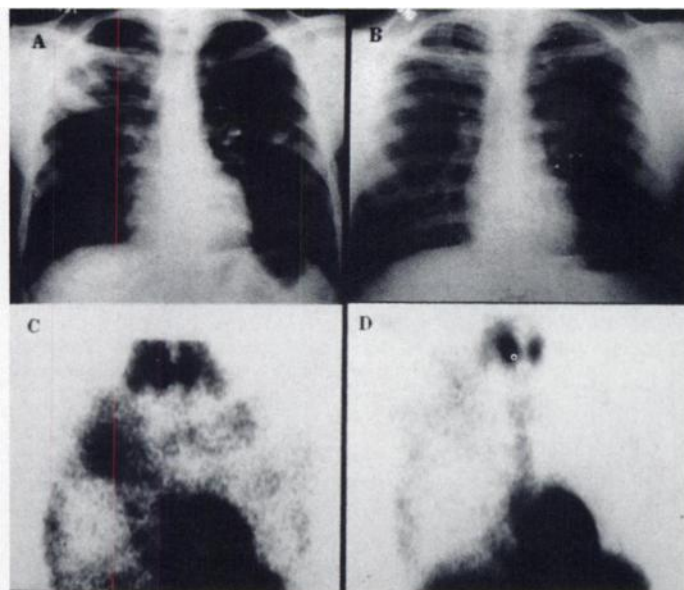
Technetium-99m-tetrofosmin scintigraphy and planar chest radiographs of 16-yr-old boy before and after chemotherapy treatment. (A) Before therapy, there was cavitory lesion with fibronodular infiltration on right upper lung and fibronodular infiltrations on left upper-middle lung zones on chest radiograph. (B) After therapy, lesions disappeared on chest radiograph. (C) Before therapy, ^{99m}Tc-tetrofosmin scintigraphy shows increased radiopharmaceutical uptake on right upper lung extending to medial part of right middle lobe and left upper-middle lung zone. (D) After treatment, there was no pathological radiopharmaceutical uptake in the lung, which may be related to APTB.
